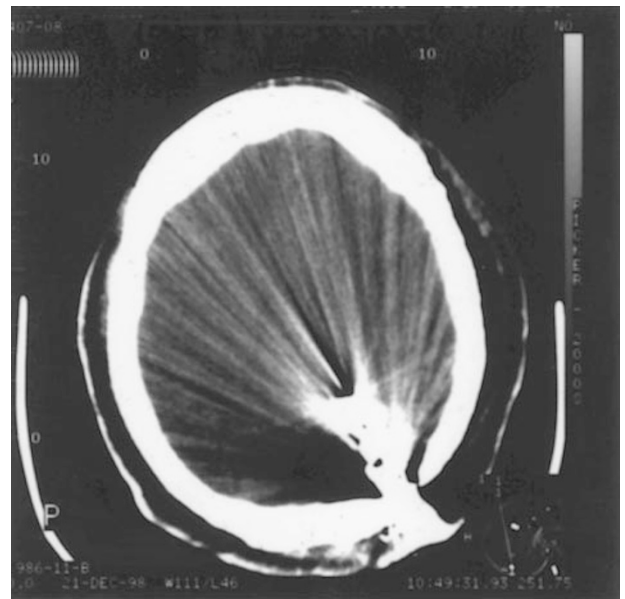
Head CT scan showing a skull fracture and metallic artifact from a bullet
